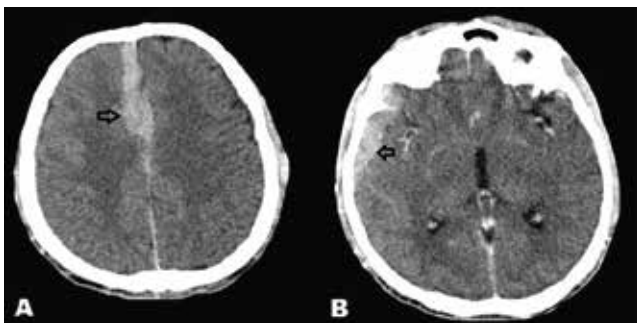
2- Axial CT post contrast brain images showing enhancement of the extra axial lesions – [arrows in Fig. A & B].
